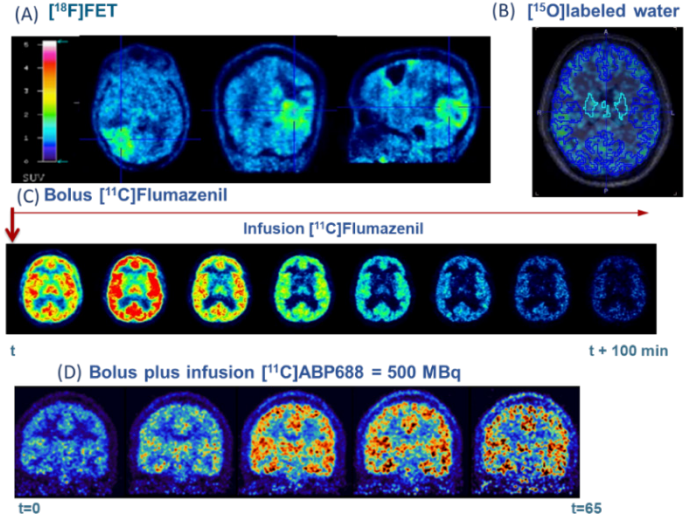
Different quantitative and pseudo-quantitative PET images. (A) Summed images from 20-40 minutes of $[^{18}\text{F}]\text{-FET-PET}$ measurements in SUV units. (B) Image showing the activity concentration kBq/cm^3 of $[^{15}\text{O}]\text{H}_2\text{O}$ measurement with regions for gray matter (blue lines), and white matter (turquoise lines). (C) Images of dynamic $[^{11}\text{C}]\text{Flumazenil}$ measurements using a bolus-infusion protocol. Shown an activity concentration in kBq/cm^3 . (D) Images of dynamic $[^{11}\text{C}]\text{ABP688}$ measurements using a bolus-infusion protocol. Shown quantity of activity concentration in kBq/cm^3 . Adapted from (Régio Brambilla et al. 2022) & (Issa et al. 2023).
